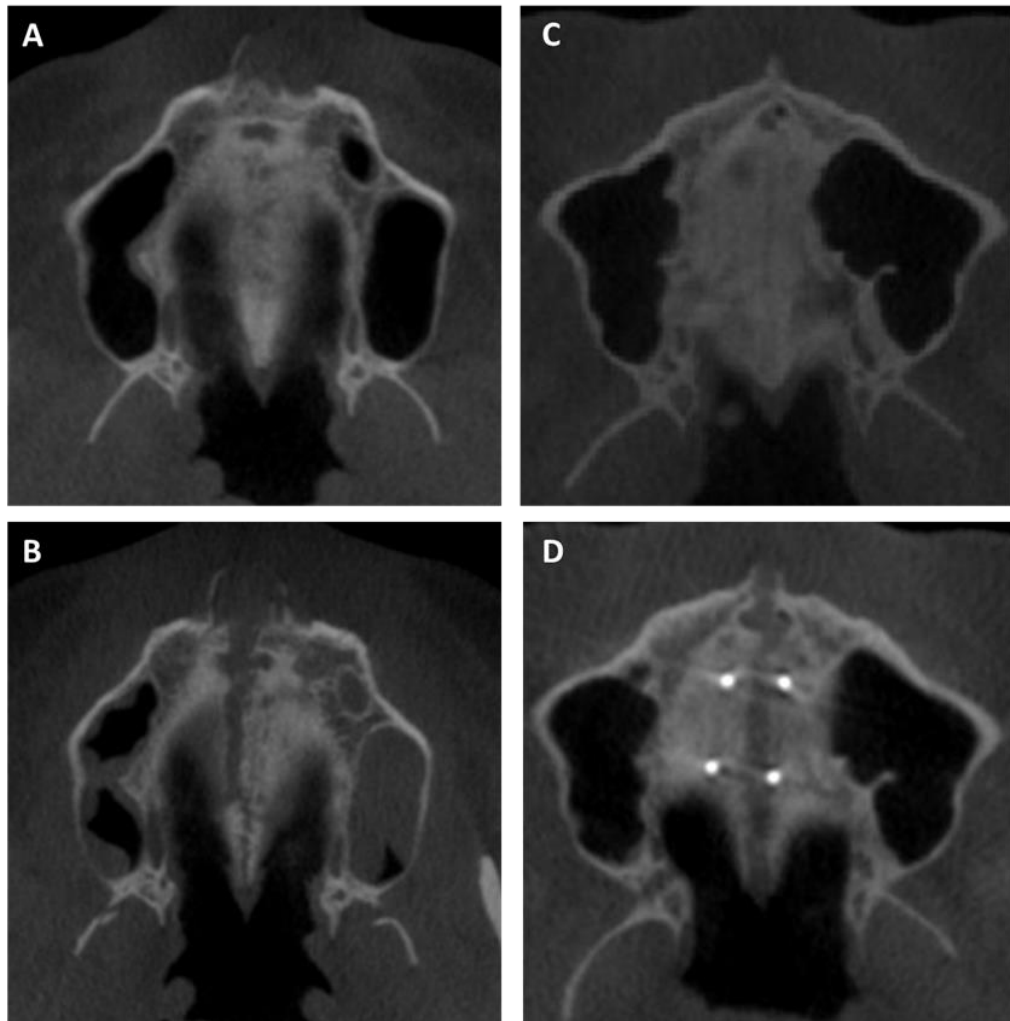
Axial views of CBCTs comparing the opening patter of SARPE and MARPE techniques: A, SARPE case before expansion (T0); B, SARPE case after expansion (T1) showing the “v shape” patter of opening; C, MARPE case before expansion (T0); D, MARPE case after expansion (T1) showing a parallel pattern of opening.
